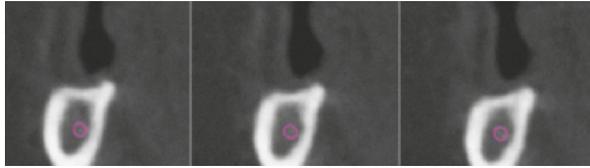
CBCT cross section of posterior mandible site. Note the extreme vertical ridge deficiency. A decision has to be made between short implants vs. staged vertical augmentation.
